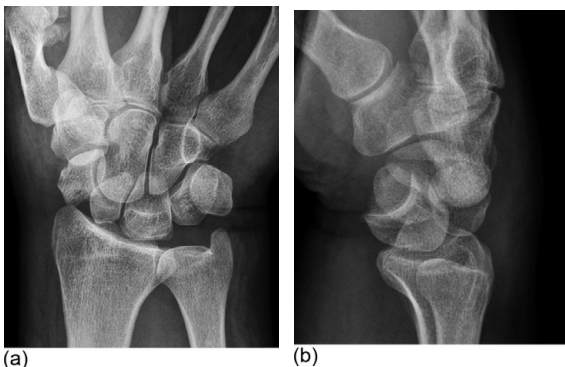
(a) Posteroanterior and (b) lateral radiograph wrist
